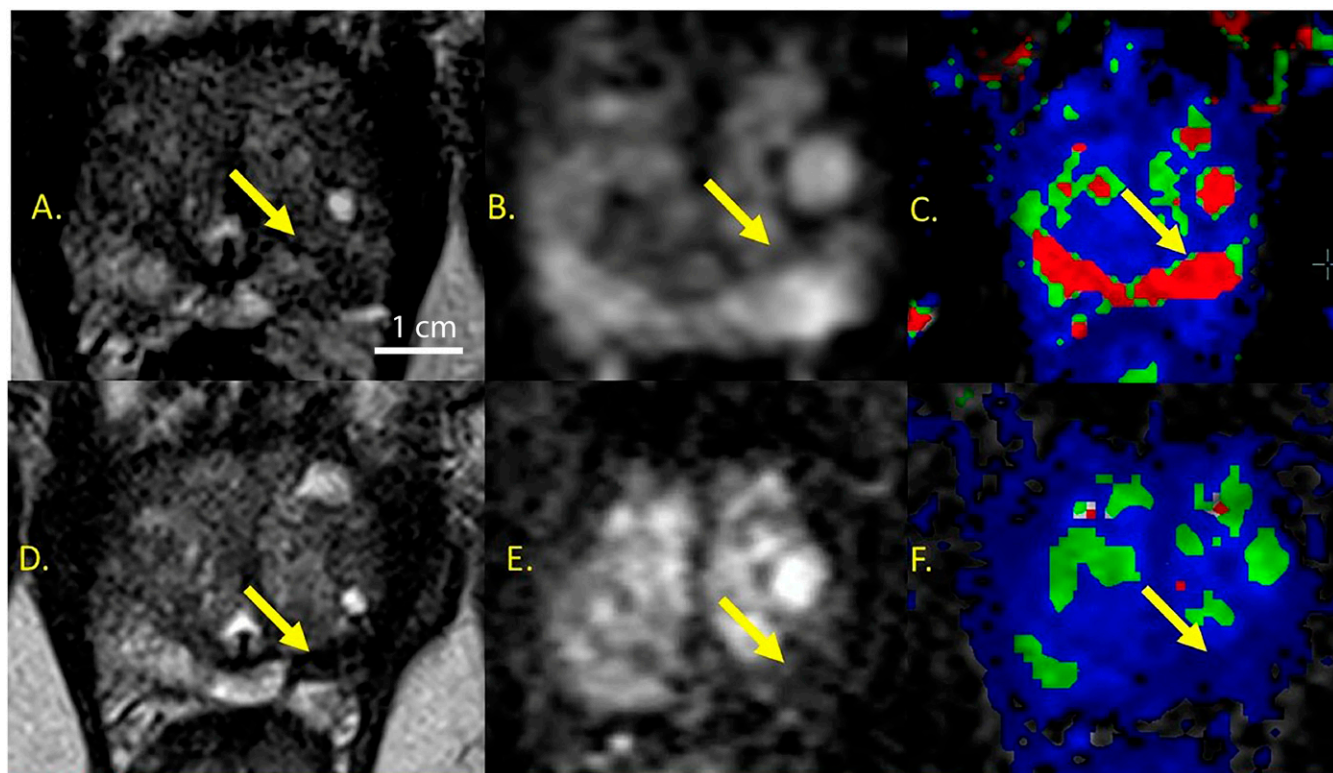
Representative case of a 70-y-old man with focal prostate cancer treated successfully with GSN-directed laser excitation and ablation (A–C) pretreatment, (D and E) 3 mo posttreatment. Follow-up biopsy at 3 mo was negative for cancer. (A) Axial T₂-weighted image demonstrating left apex tumor Gleason 3+4 on targeted biopsy (arrow). (B) DWI image for $b = 2,000$ demonstrates restricted diffusion in tumor (hyperintensity compared to normal peripheral zone). (C) DCE-MRI parametric map (K_{trans}/V_e) demonstrates increased enhancement of the tumor. (D) Axial T₂-weighted image after treatment demonstrating contraction of ablation zone, appearing markedly hypointense, compatible with hemorrhagic/necrotic changes. (E) DWI image for $b = 2,000$ demonstrates resolution of restricted diffusion in treated tumor (arrow). (F) DCE-MRI parametric map (K_{trans}/V_e) demonstrates resolution of abnormal enhancement in treated tumor (arrow). (Scale bar: 1 cm.)
